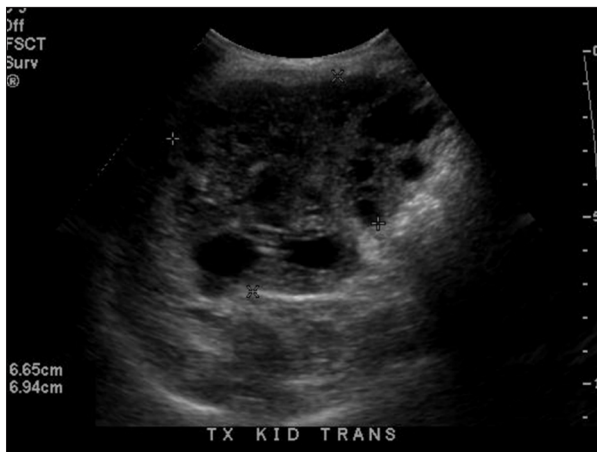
Ultrasound image from Case 2 showing multiple cysts throughout the kidney transplant replacing the normal renal parenchyma.
